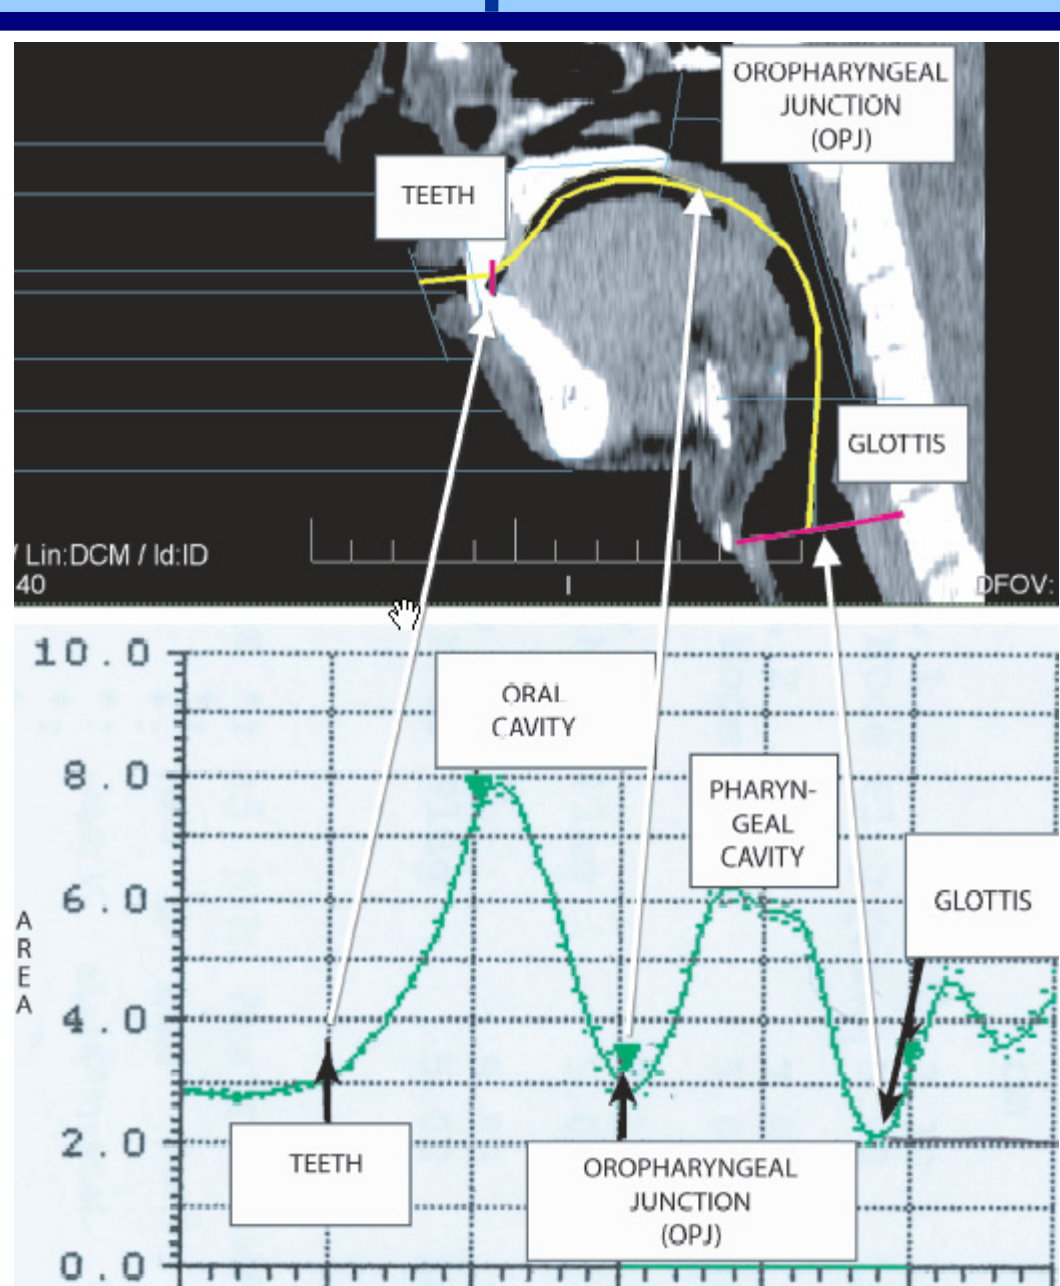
CT (top) and ART (bottom) equivalent anatomic landmarks from the same subject.
